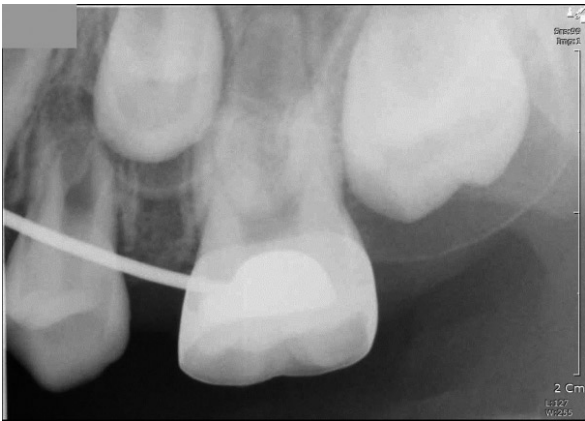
At 30 months after surgical removal of ankylosed tooth; Periapical view shows the movement of permanent successor tooth germ in alveolar bone.
